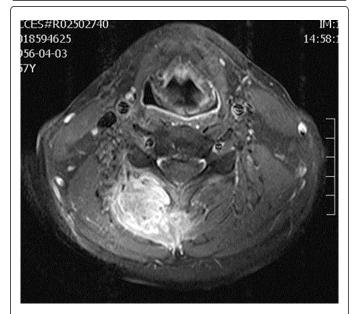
Axial image of cervical MRI when the patient finished radiotherapy
